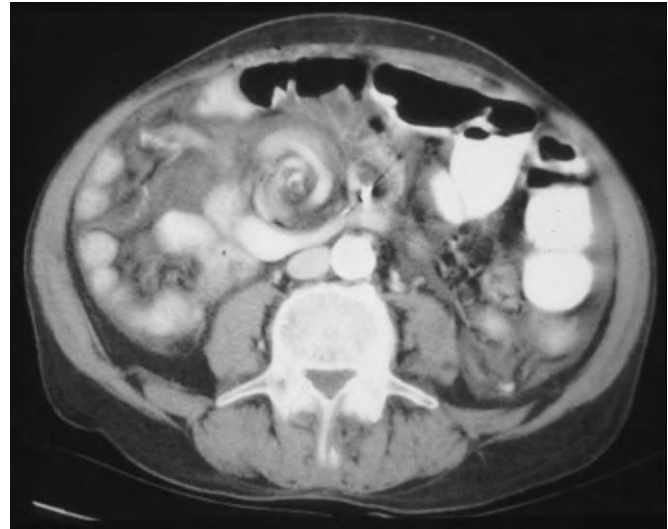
Abdominal computed tomography scan with a “whirl” sign in a patient with small bowel volvulus secondary to postoperative adhesions.
